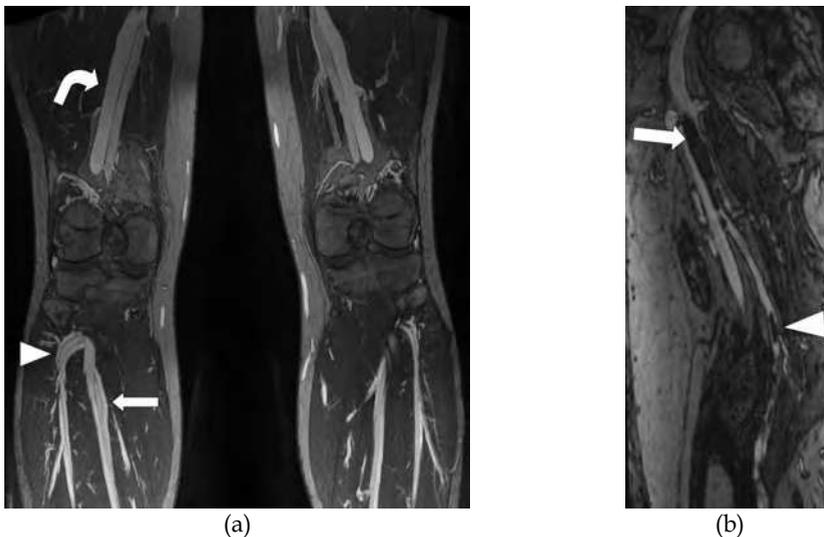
High resolution MRI using “blood pool” contrast allows excellent visualisation of both veins and their accompanying arteries. (a) Coronal plane. The normal anatomy of the calf arteries with their accompanying paired veins is clearly demonstrated with the anterior tibial artery and veins (*arrowhead*) and the peroneal artery and veins (*straight arrow*). The superficial (deep) femoral vein and artery are also shown (*curved arrow*). (b). Sagittal oblique view showing clot within the common femoral vein (*arrow*) and great saphenous vein (*arrowhead*).
